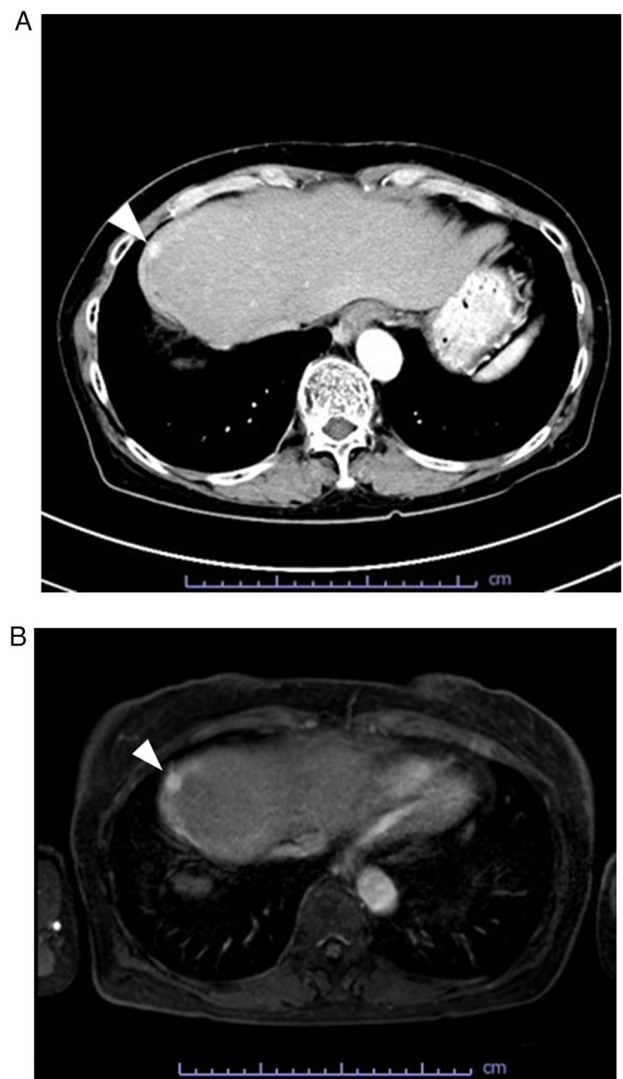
(A) Abdominal enhanced computed tomography and (B) T1-weighted magnetic resonance tomography before the first operation. The images show a nodule with early enhancement in the segment four area, in the arterial phase. Arrowheads indicate the tumor.
